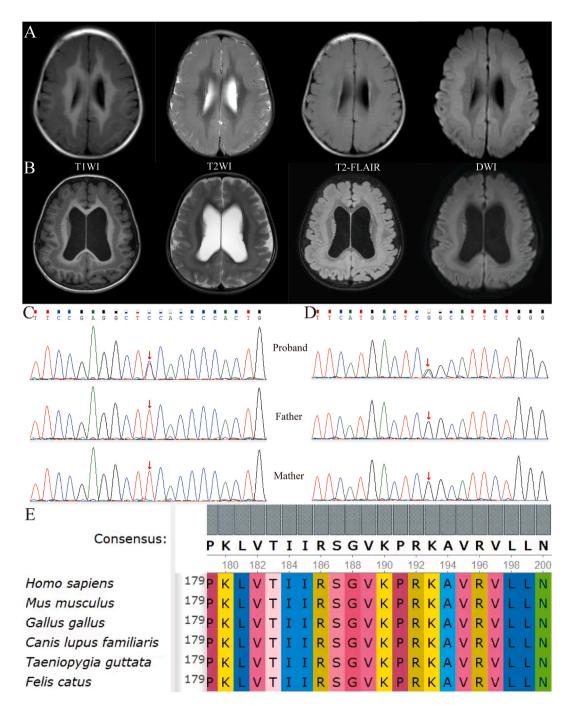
Clinical data of two patients. (A) Brain MRI of P1 showed partial cortical thickening and increased regional gyri. The banded cortical signal shadows were seen in the medulla. (B) Brain MRI of P2 showed local gyri widening and broad bands of gray matter signals in the white matter. (C–D) Heterozygous mutations of c.568A > G and c.814C > T were found in P1 and P2, respectively. (E) Conservative analysis showed the Lysine 190 is highly conserved in different species.
